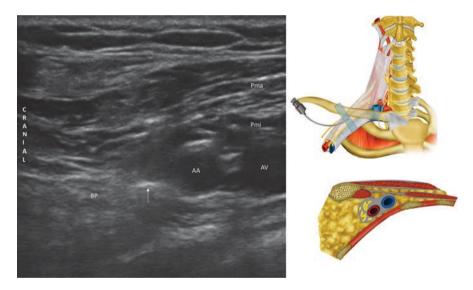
Ultrasound of infractavicular area and out of plane needle placement inside brachial plexus sheath between plexus and artery. *BP* brachial plexus; *AA* axillary artery; *AV* axillary vein; *Pma* pectoralis major; *Pmi* pectoralis minor; white arrow – needle
